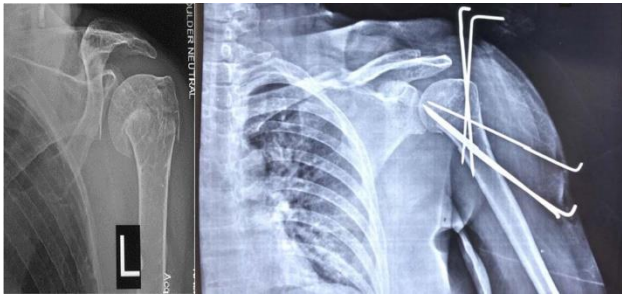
Pre and post-operative X-ray of a K wiring case.
